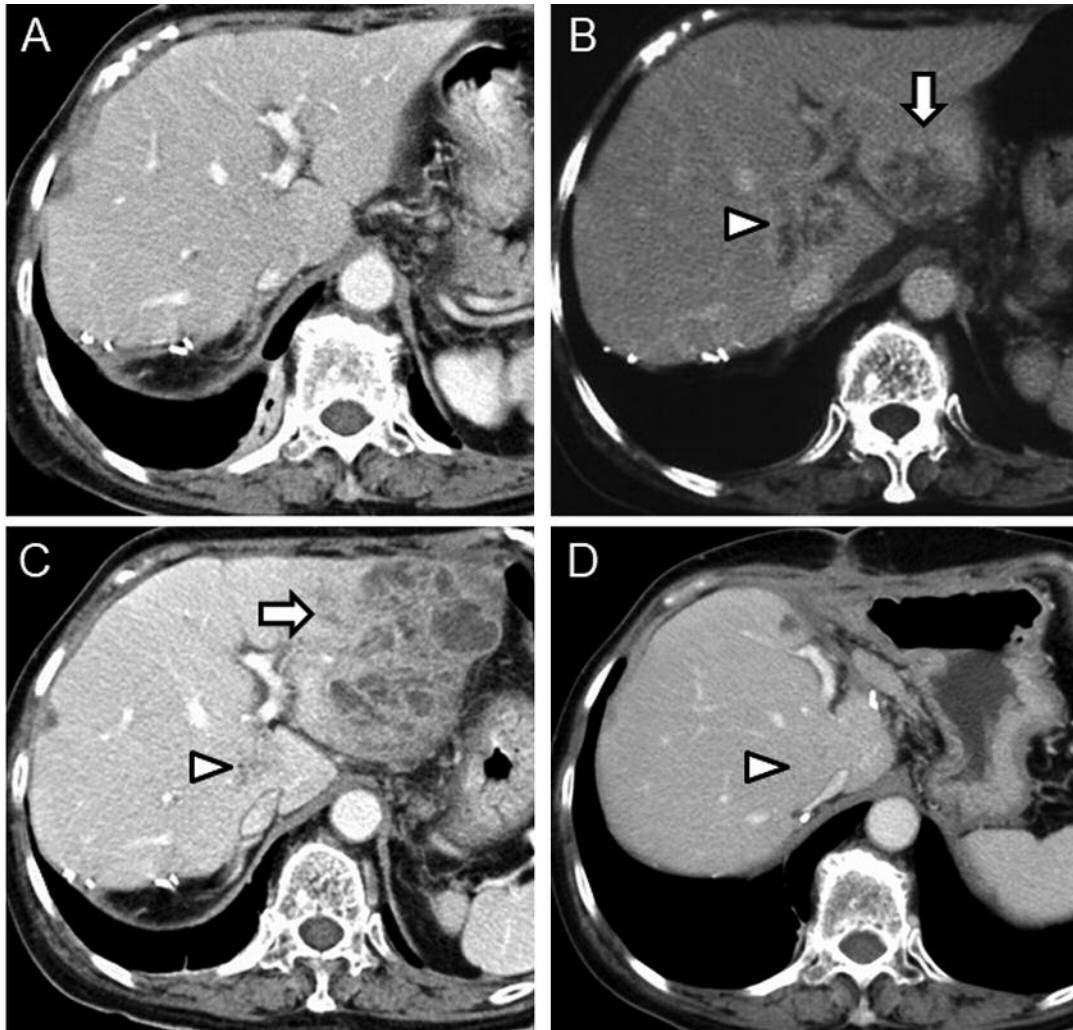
Contrast-enhanced computed tomographic findings before (A, B, C) and after (D) second hepatectomy. Two reticular mass lesions suddenly appeared in the left lateral sector (arrow) and caudate lobe (arrowhead) 2 months before the second hepatectomy (A and B). The lesion in the left lateral sector rapidly developed within 1 month of the second hepatectomy to occupy most of the hepatic parenchyma (C). The lesion in the caudate lobe gradually vanished within 3 months of resection (D).
